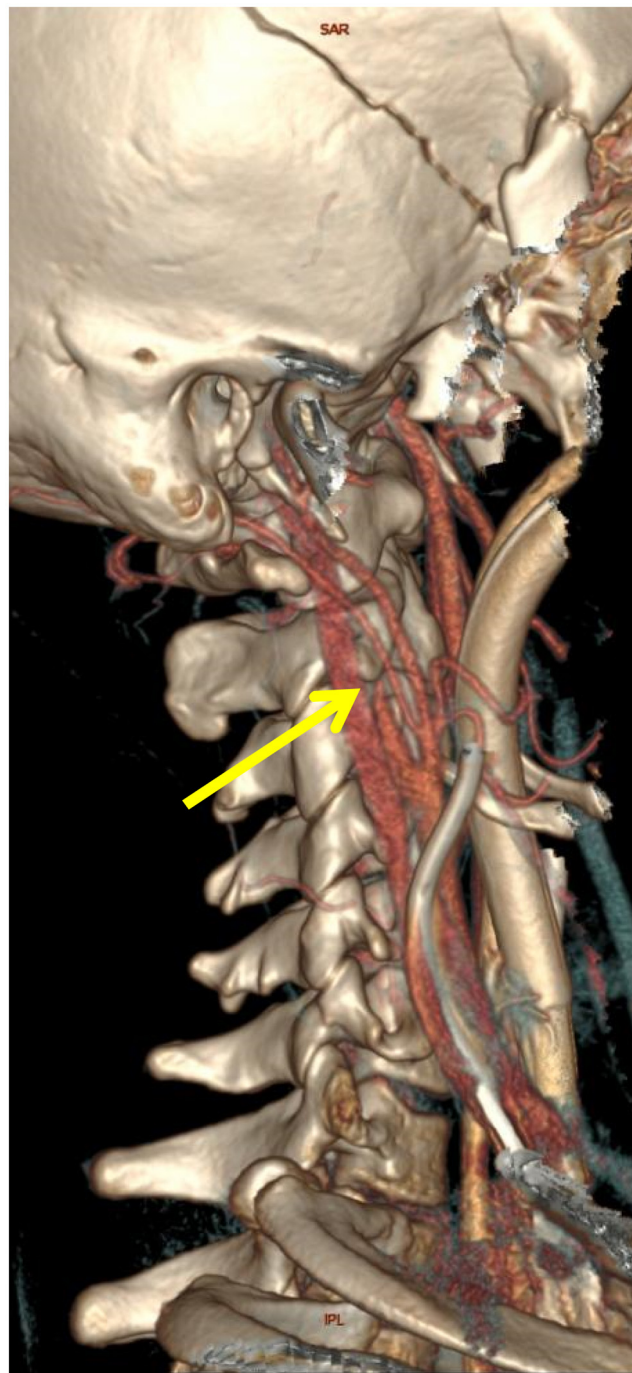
3D reformat image of Computed Tomography angiogram of the neck vessels showing gradual tapering of the proximal right internal carotid artery (arrow) and complete occlusion of the internal carotid artery distally indicative of dissection.
